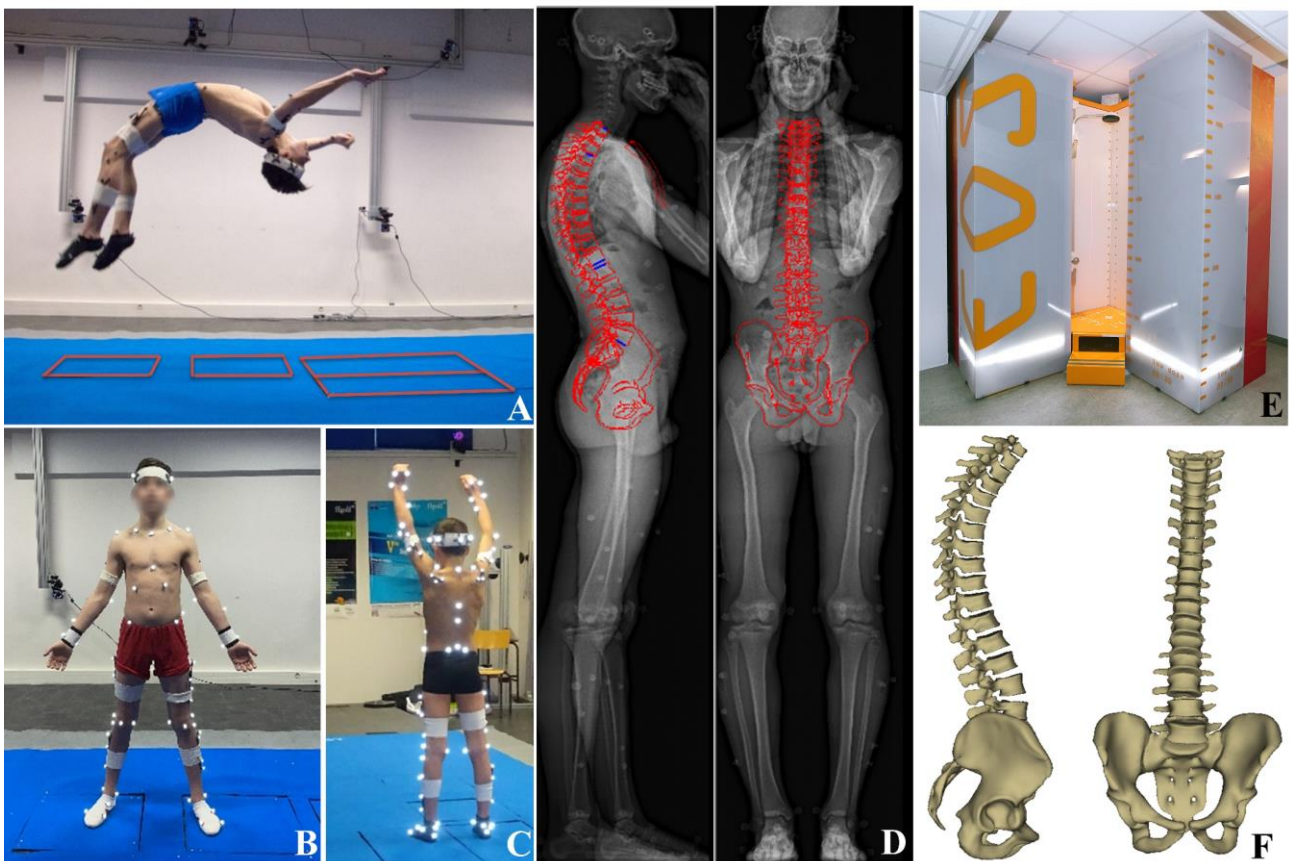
Photographs during experimental sessions: (A) Back handspring execution in the motion analysis lab equipped with four force-plates (delimited by red lines on the image), (B) Static acquisition in upright standing posture, (B & C) Set of reflective markers in anterior and posterior views, (D) Biplanar radiographic acquisitions in neutral standing upright posture with retro-projected
